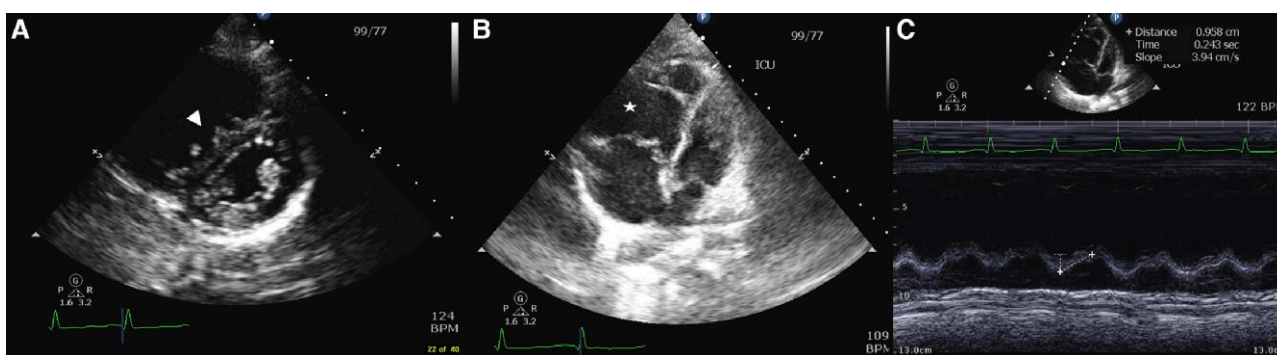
Admission transthoracic echocardiogram (TTE): (A) parasternal short axis view with D shaped (arrowhead) left ventricle. (B) Apical four chamber view with an enlarged right ventricle (star). (C) Tricuspid annulus planar systolic excursion (TAPSE) severely reduced to 0.95 cm. TTE, transthoracic echocardiogram; TAPSE, tricuspid annulus planar systolic excursion.
